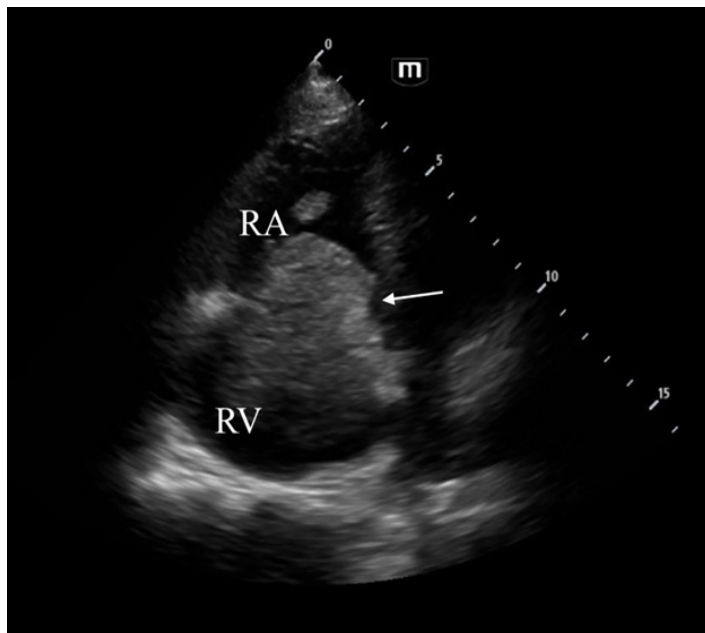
Point-of-care ultrasound image in apical 4-chamber view demonstrating dilated right ventricle (RV) with a large mass (indicated by arrow) extending from the right atrium (RA) into the right ventricle through the tricuspid valves.
